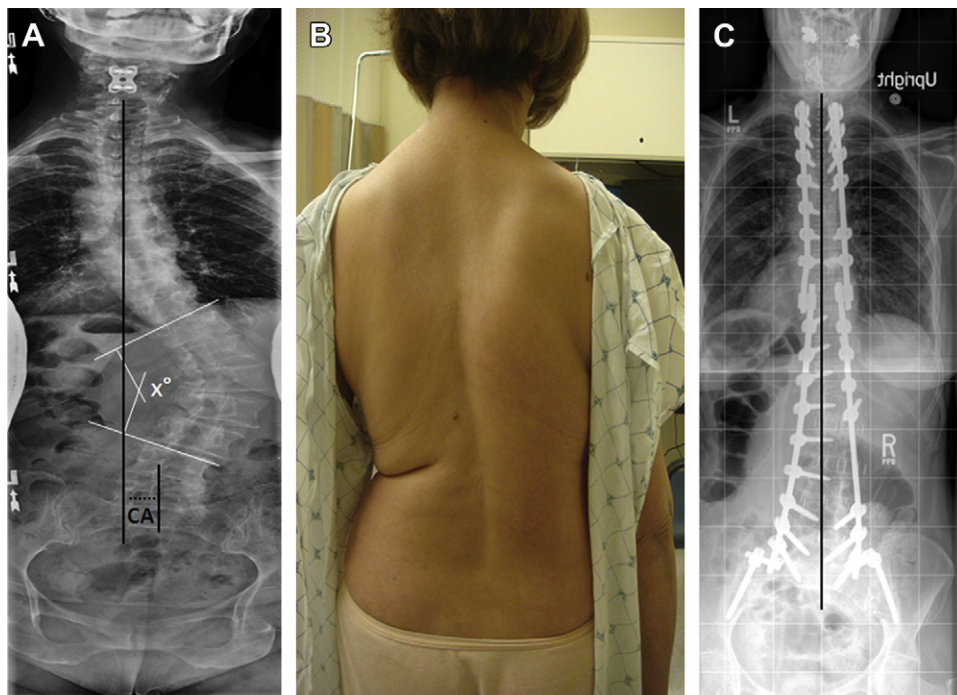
Clinical photographs and radiographs of a 52-year-old woman presenting with back pain and right lower extremity radicular pain. (A) Preoperative posteroanterior radiograph demonstrates a dextroscoliosis with an apex at L1-2. X, coronal Cobb angle measurement. The C7 plumb line and central sacral vertical line are shown in black, and the distance between these (the coronal alignment [CA]) is depicted by the horizontal dashed line. In this case the CA is a negative value (−2.8 cm) because the C7 plumb line falls to the left of CSVL. Findings on clinical assessment are subtle. (B). Postoperative full-length posteroanterior radiograph following instrumented correction of the deformity (C). The C7 plumb line is shown in black and demonstrates restoration of CA.
